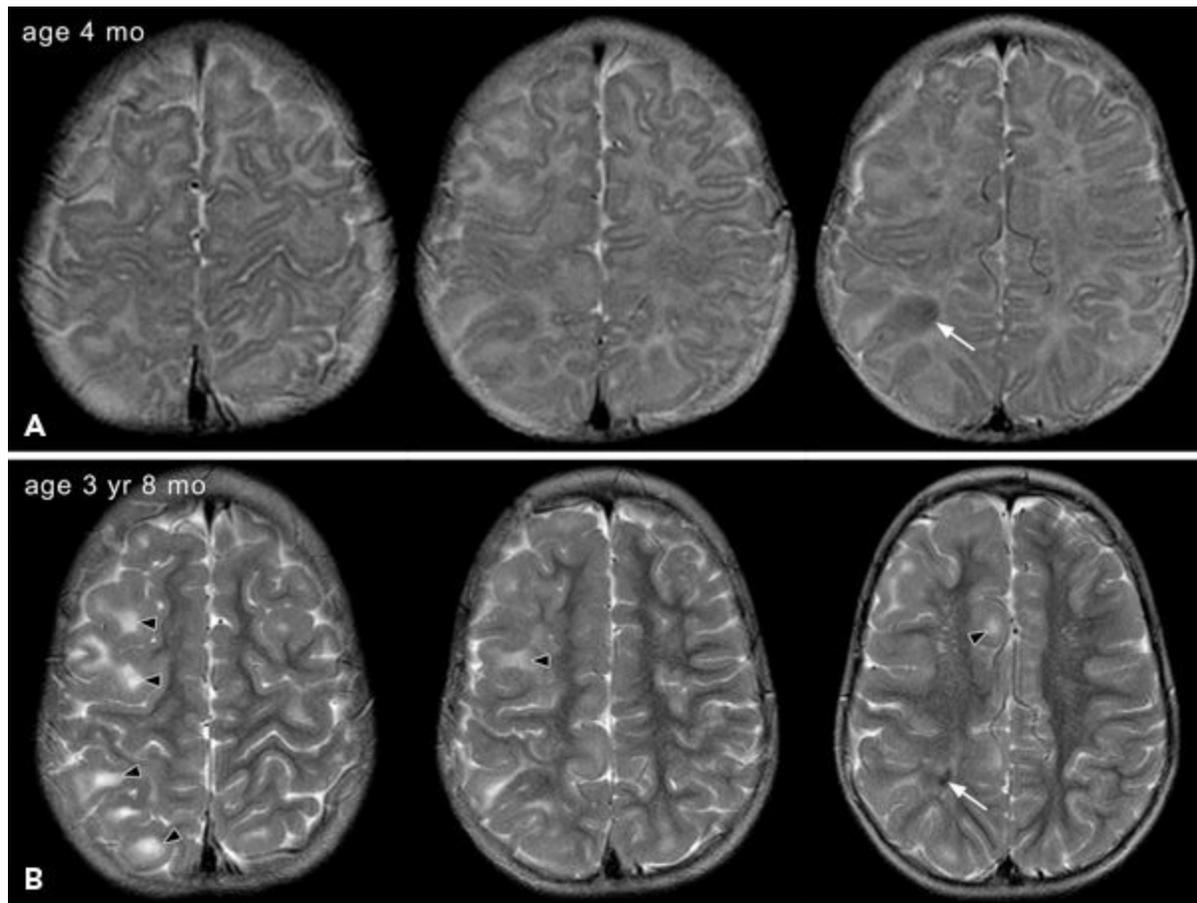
MRI in a child with tuberous sclerosis performed at 4 months of age (A) and at 3 years and 8 months of age (B). Cortical and subcortical tubers (arrowheads) were more evident on follow-up imaging because of myelination of white matter, improving the “background contrast.” Increase in size of lesions with brain growth, calcification (arrow), and abnormal myelination around the lesions may also contribute to better visibility on follow-up MRI. (Courtesy of Dr. Ajay Gupta, Cleveland, OH.)
